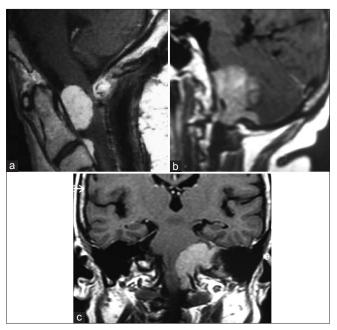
Example of the last cases seen by the authors. Sagittal view of head magnetic resonance imaging showing a meningioma arising below the foramen magnum, the Spinocranial type (a). A craniospinal type 2 foramen magnum meningioma, reaching above the pontomedullary sulcus on sagittal and coronal views (b and c).
